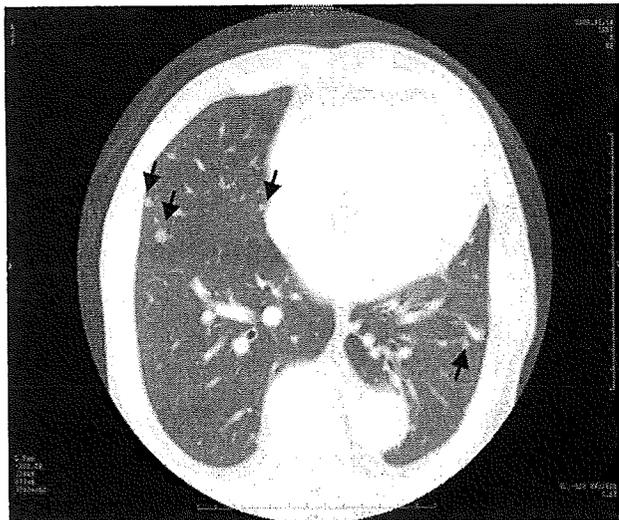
Chest CT scan revealed multiple lung nodules indicative of multiple lung adenomas.
